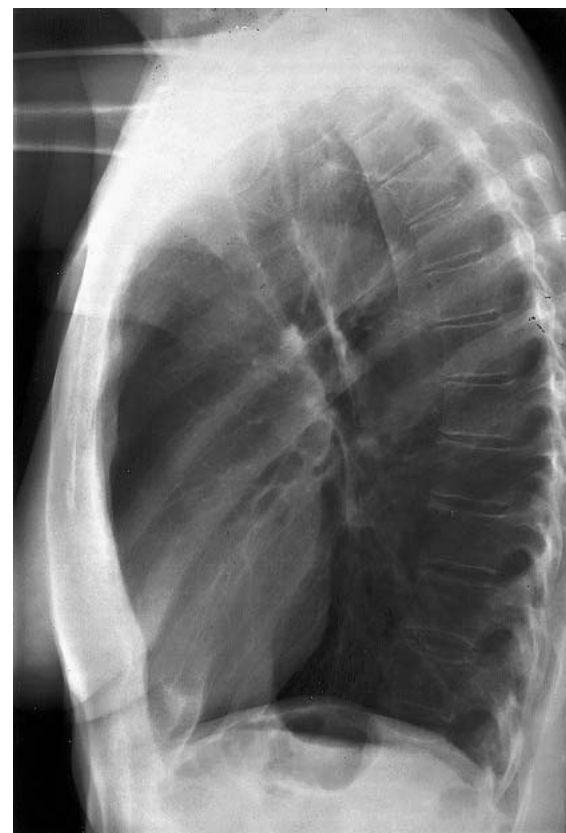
Lateral chest radiograph (normal)
